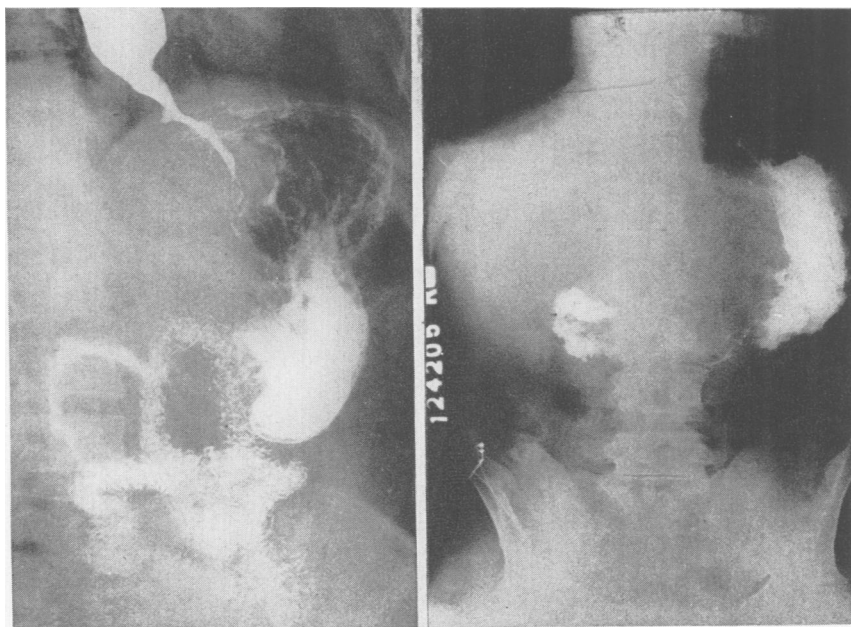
Case 1: Roentgenogram showing filling defect in the cardia of the stomach, with narrowing and irregularity of the lower end of the esophagus and a penetrating defect of the lower border of the tumor.
